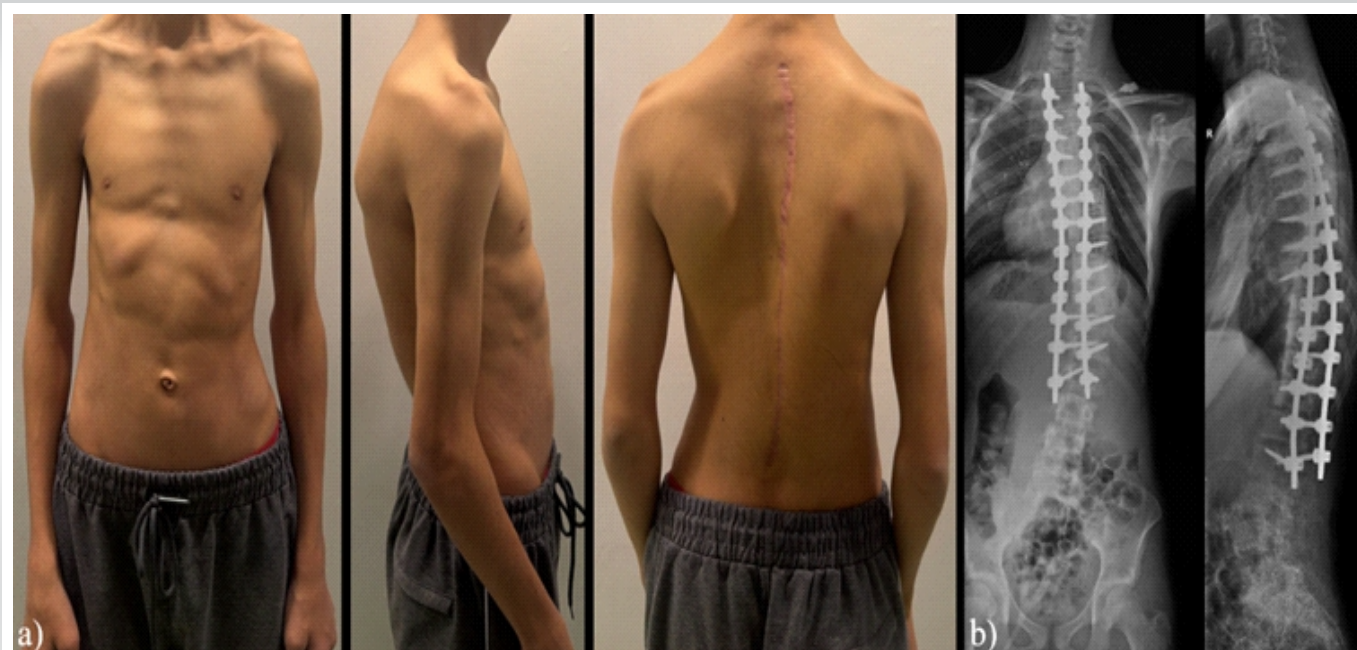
Post-operative clinical and radiographic outcomes. (a) Standing post-operative clinical photographs obtained in the anterior, lateral, and posterior views. (b) Standing postoperative full-length scoliosis radiographs in the coronal and sagittal planes (anteroposterior/posteroanterior and lateral views).
